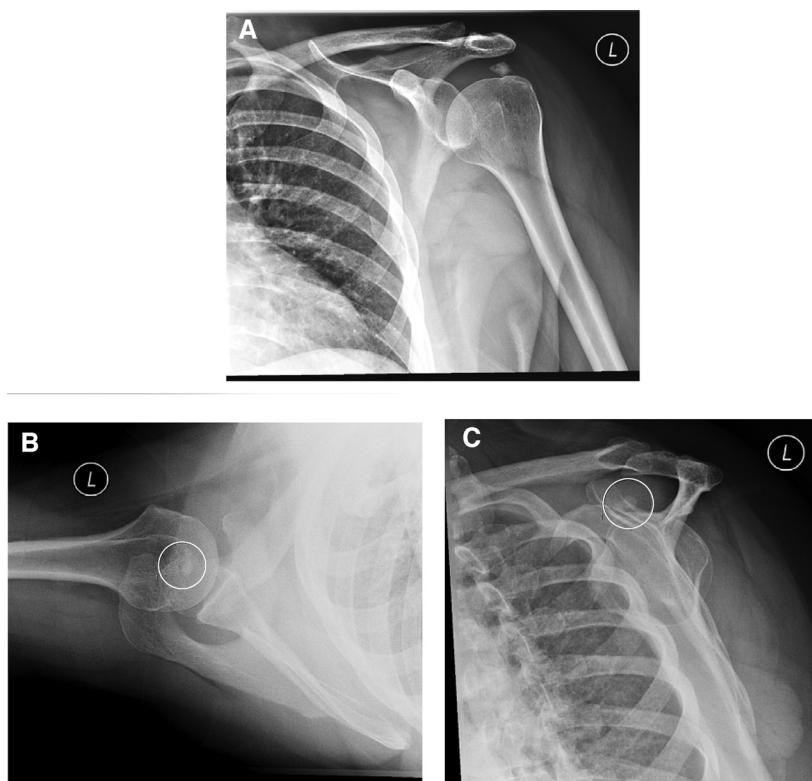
Anteroposterior (A), axillary (B), and Y-view (C) radiographs of the left shoulder. Note calcified body in the subacromial space, denoted with ellipse on the axillary and Y-view radiographs.
